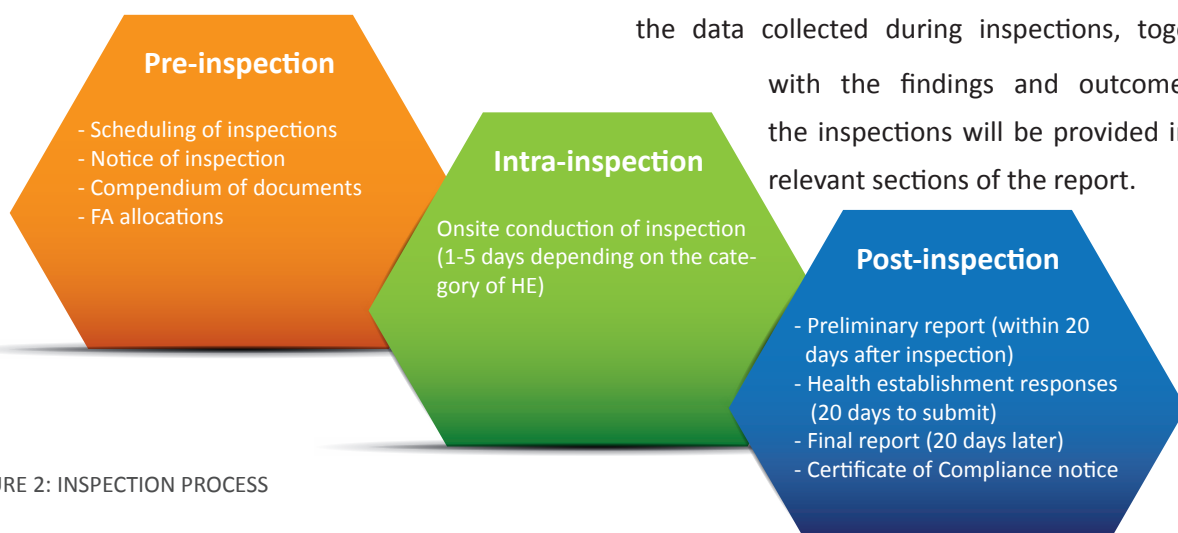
INSPECTION PROCESS
